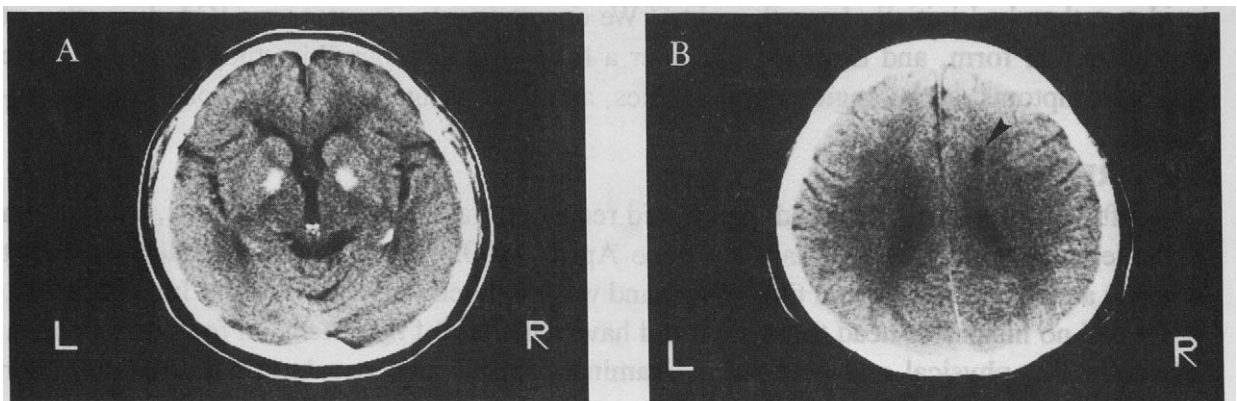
A.B. Brain CT showed the bilateral calcifications of the basal ganglia and a small low density lesion (arrow head) beside the right lateral ventricle.
